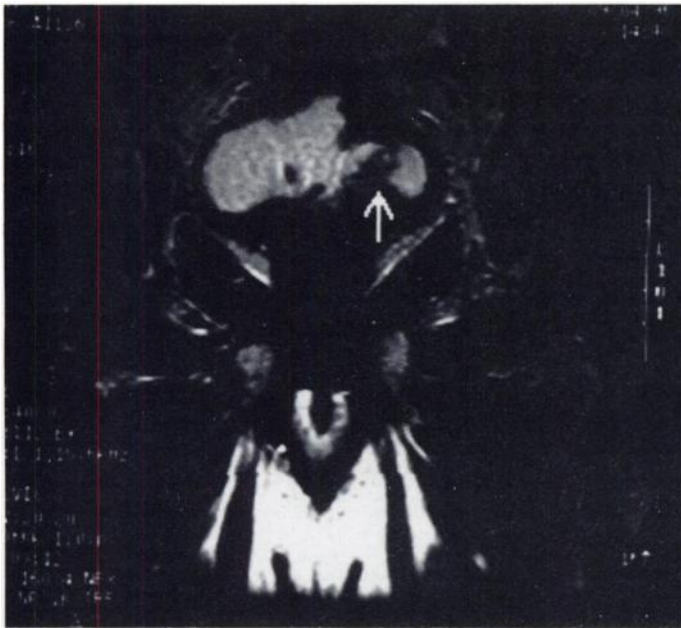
MRI of the pelvis demonstrates recurrent tumor in base of the bladder (arrow).
